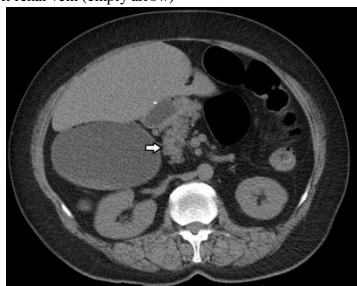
Axial section non-contrast CT showing vertically oriented short pancreas (white arrow)
